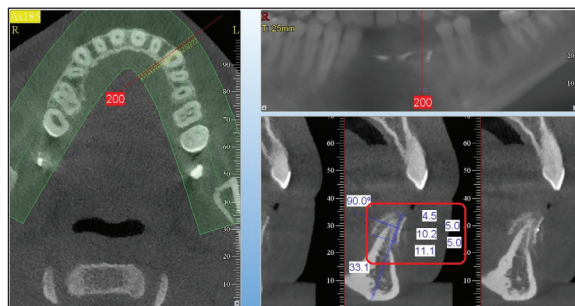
CBCT scan – width measurements at points 0, 5 and 10.
